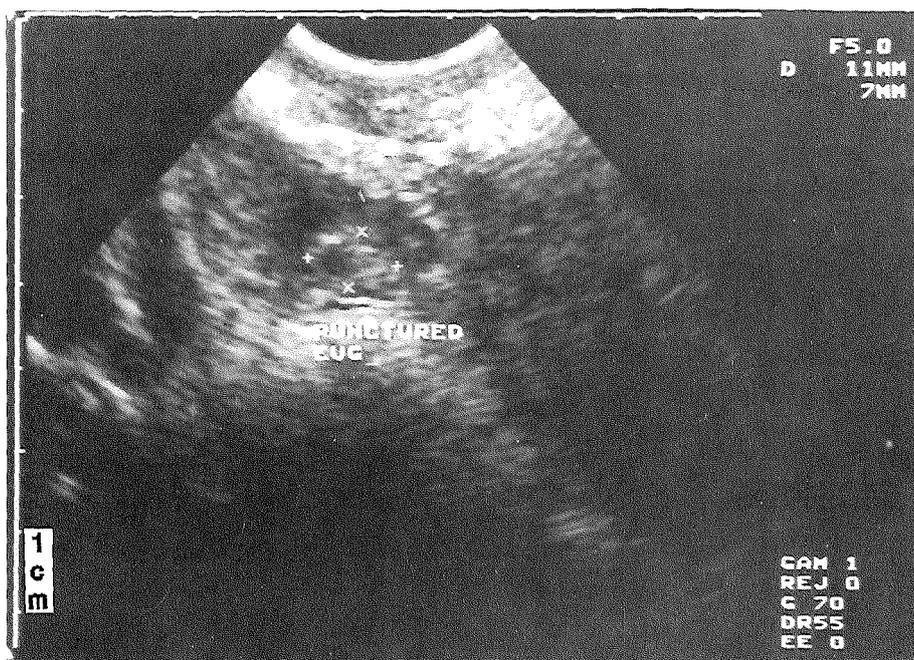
Transvaginal sonographic presentation of a punctured ectopic pregnancy (Patient No. 3). EUG = ectopic pregnancy.
